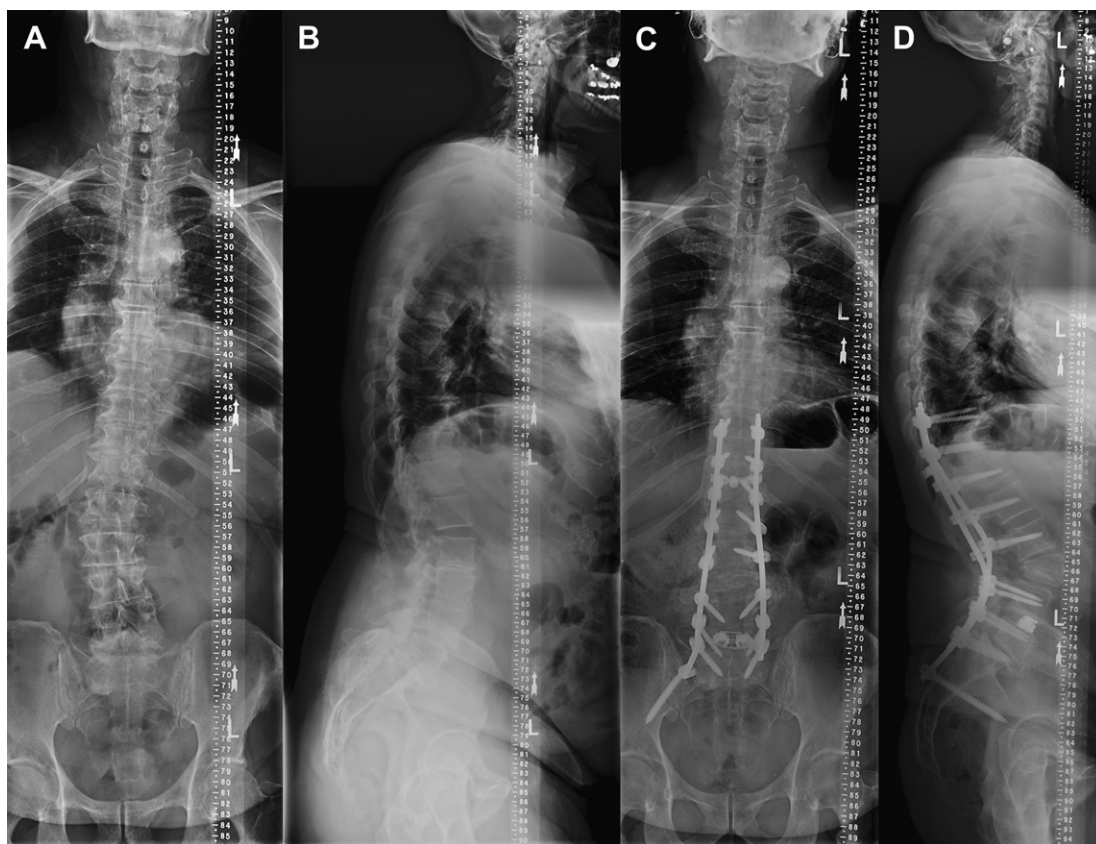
A 64-year-old man presented with low back pain and inability to stand upright for long. (A, B) His 91.44-cm (36-in) radiographs showed significant sagittal imbalance (SVA = 8.5 cm). (C, D) Postoperative 91.44-cm (36-in) radiographs after an L3 pedicle subtraction osteotomy with T10 to S1 pedicle screw fixation and extension to right iliac (MiSLAT VI treatment).
